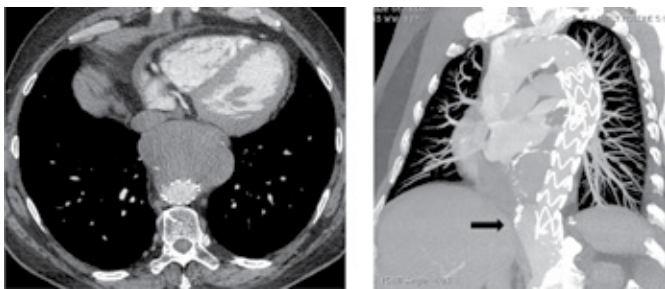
Post-TEVAR CTA showing thrombosis of the thoracic aneurysm but with some retrograde flow in the false lumen next to the last stent of the endograft (arrow).
